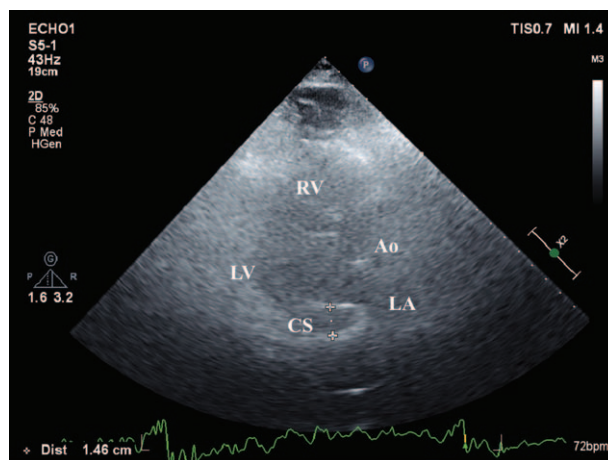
Parasternal long axis view of transthoracic echocardiography showed a dilated coronary sinus (1.46 cm). Ao=aorta, CS=coronary sinus, LA=left atrium, LV=left ventricle, RV=right ventricle.
